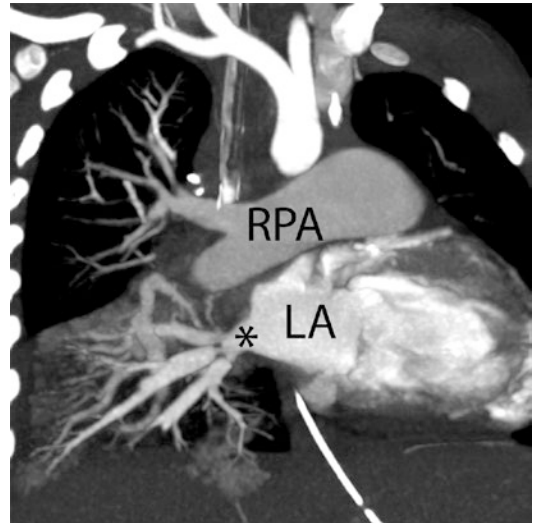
CT, pulmonary vein stenosis. The coronal multiplanar reformat of the computed tomography angiogram demonstrates severe focal stenoses (asterisk) of all three contributors to the right lower pulmonary vein in a 3-year old. The right pulmonary artery is enlarged, secondary to pulmonary hypertension. The other three pulmonary veins were also obstructed. The stenoses recurred following surgical and catheter interventions and the patient eventually received a heart and lung transplant. LA left atrium, RPA right pulmonary artery
